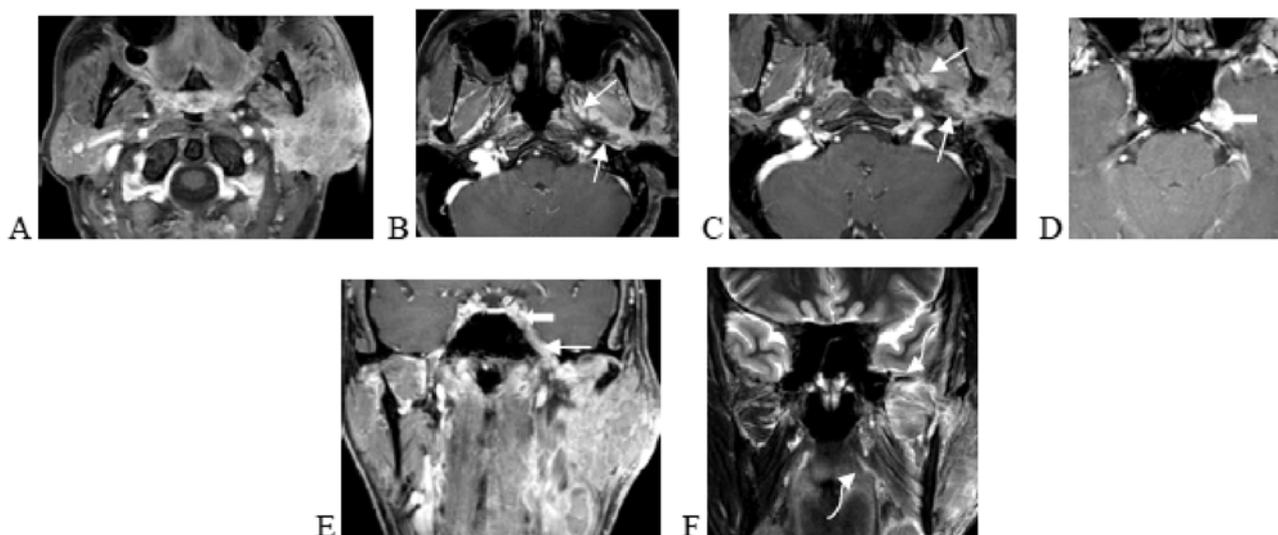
Case 4: perineural tumor spread (PNS): A 57-year-old male presented with 2 months of palpable left parotid mass. MRI of the nasopharynx axial (A, B, C and D) coronal (E) post gadolinium T1WI and coronal T2WI (F) shows ill-defined heterogeneously enhancing infiltrative lesion involving entire left parotid gland (A) with tumor extension into posterior left cavernous sinus and Meckel cave (D and E, thick white arrows) by along mandibular branch of left CN V and via left auriculotemporal nerve behind the mandibular angle (B, C and E, white arrows) together with evidence of denervation of muscles of mastication on the left side (F, curve arrow).
